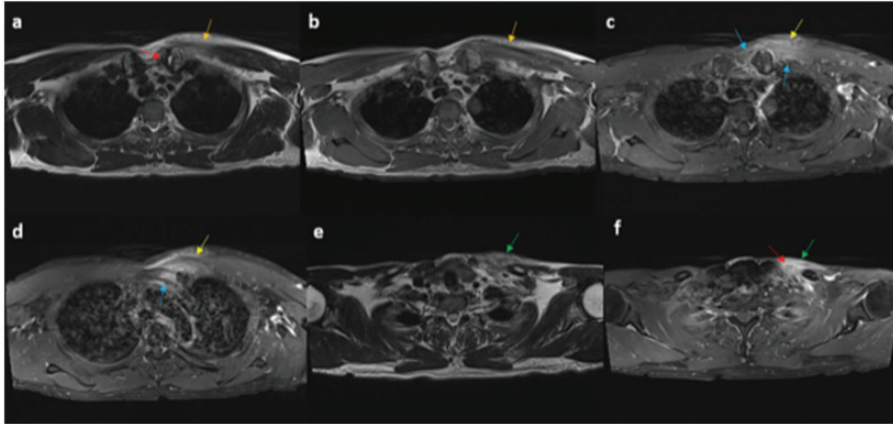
Follow-up images of the patient 20 days after the initial pain onset (a) Axial T2-weighted and (b) T1-weighted magnetic resonance imaging (MRI) showing fluid within the left sternoclavicular joint (red arrow) and edema of the pectoralis major and sternocleidomastoid muscles (orange arrows). (c and d) Axial fat-suppressed contrast-enhanced T1-weighted MRI showing bone marrow enhancement of the manubrium and clavicle around the left sternoclavicular joint (blue arrows). Enhancement was also seen in the left pectoralis major muscle (yellow arrow). (e and f) Axial T2-weighted and fat-suppressed contrast-enhanced T1-weighted MRI showing that the muscle edema (green) and enhancement extended to the supraclavicular area (left sternocleidomastoid muscle) (green arrows). Additionally, abscess formation (white arrow) is visible in the left sternocleidomastoid muscle.
